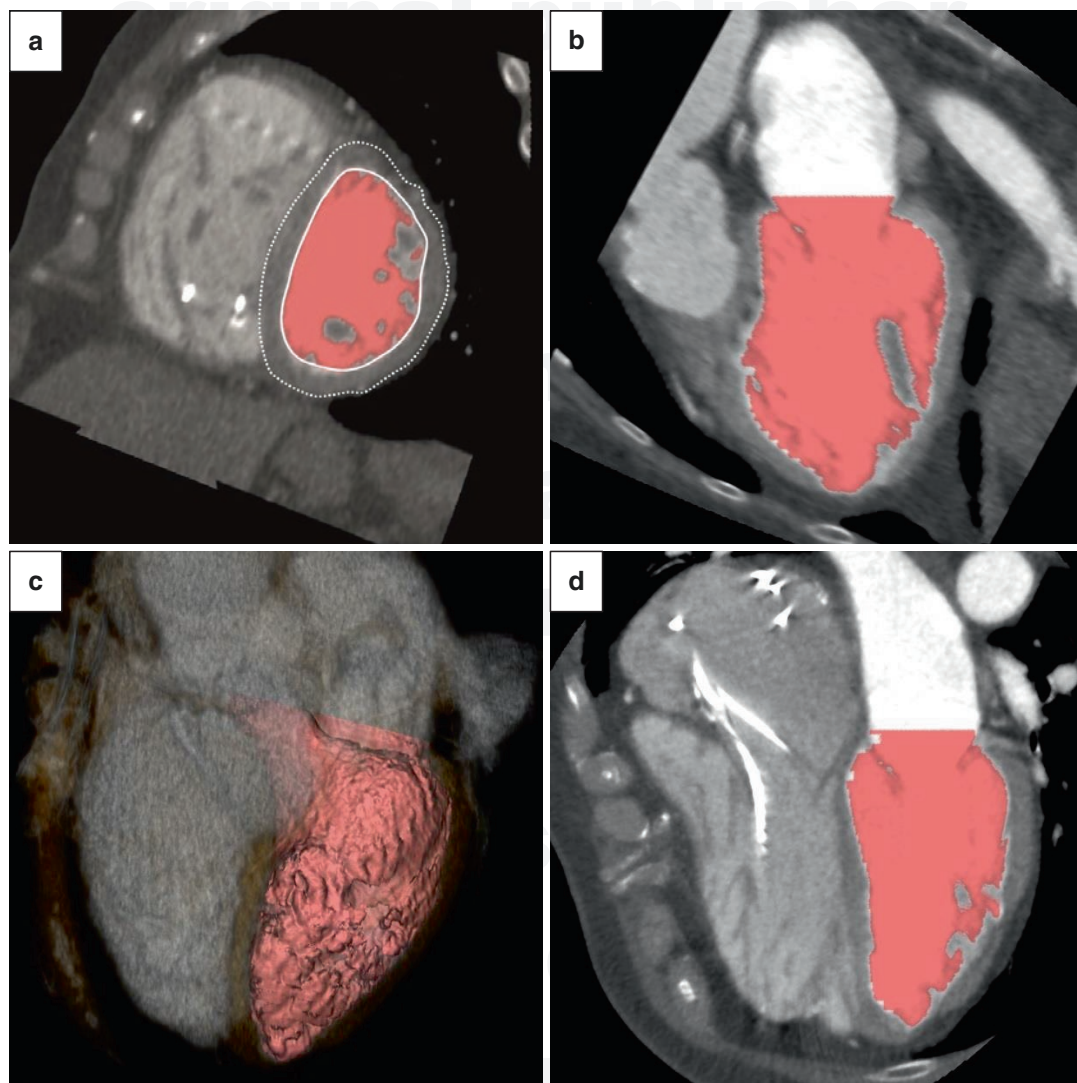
Fifty-nine-year-old female patient with corrected TOF. CT views of the left ventricle in short axis (a), vertical long axis (b, d), and volume rendering (c). Automated detection of endocardial (continuous line) and epicardial (dotted line) contours of the left ventricle (a). The ventricular volume is automatically segmented (shaded areas in a, b, c, and d), with exclusion of the papillary muscles. This is automatically performed for all available phases throughout the cardiac cycle, including end-diastolic (b)
